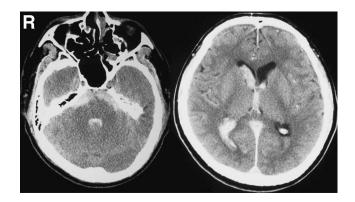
Computed tomography scans of the brain on admission showing subarachnoid hemorrhage and intraventricular hematoma.
